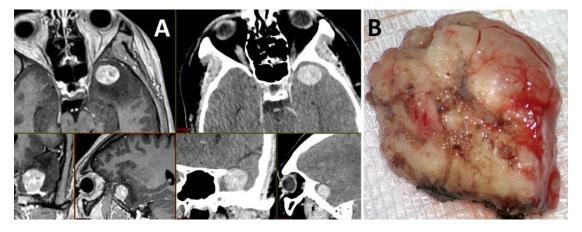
Twenty-six-year old man, inaugural grand mal seizure, WHO grade I meningothelial meningioma inserted on the temporal fossa floor. (A) MRI (left) and CT (right) scans images with contrast and (B) macroscopic appearance after removal
